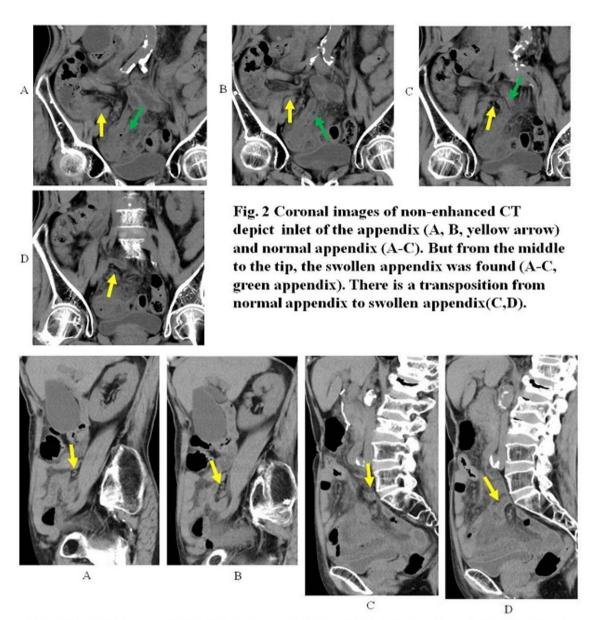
Sagittal images of non-enhanced CT depict the appendix exists in front of the right psoas muscle (A, B, yellow arrow) and there exists the dilated tubule with thick wall from the middle portion to the edge of the appendix (C, D, yellow arrow).
